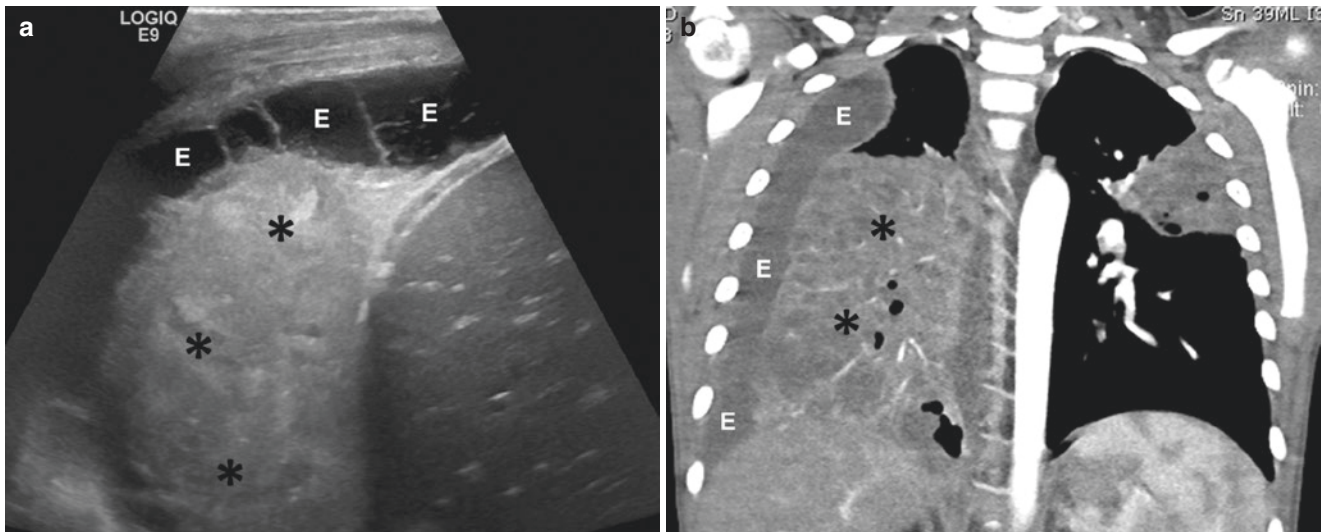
An 8-year-old boy with loculated parapneumonic effusion (E) due to necrotizing pneumonia. Ultrasound image (a) and enhanced coronal CT image (b) show loculated effusion (E) with septations and adjacent necrotizing pneumonia (asterisks)
